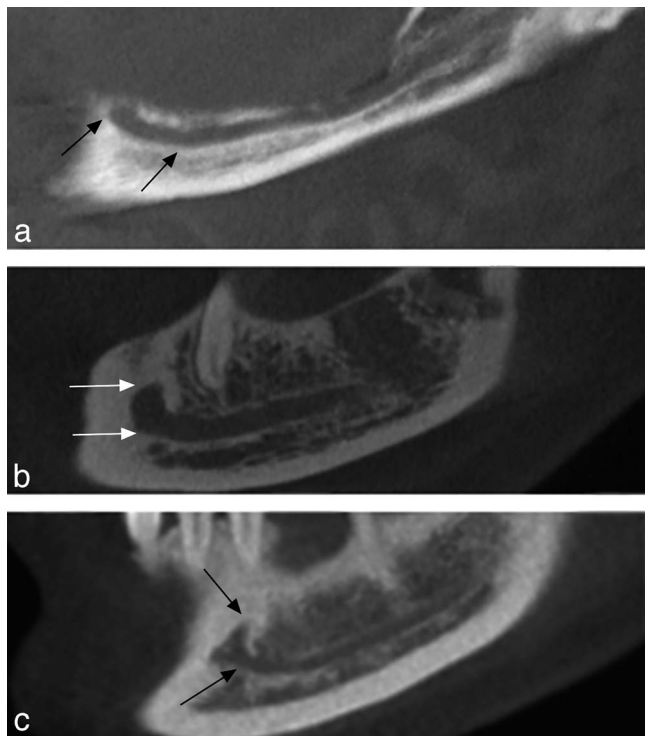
Cone-beam computerized tomography images of different patients show the straight (a), vertical (b), and anterior loop (c) types of the inferior alveolar canal. Mental portion was indicated between the arrows.
